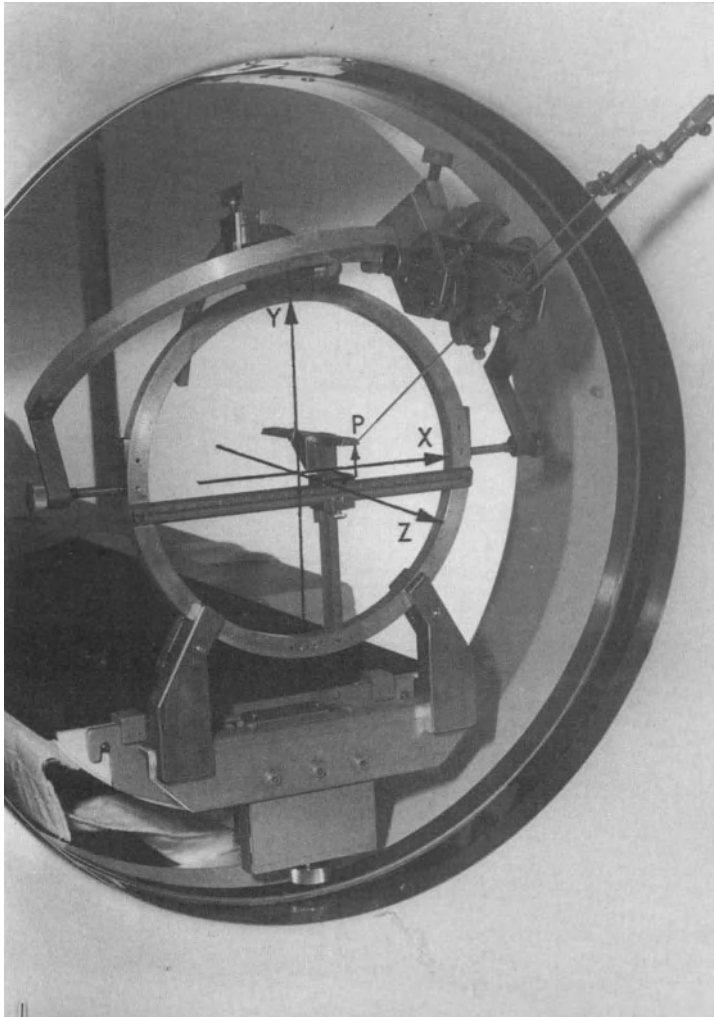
The stereotactic device inside the scanner gantry. If the zero point of the stereotactic device is in the origin of the CT scanner and the ring plane is parallel to the scan plane, the Cartesian target-point coordinates of the stereotactic device will be identical to the coordinate of the CT scanner.
